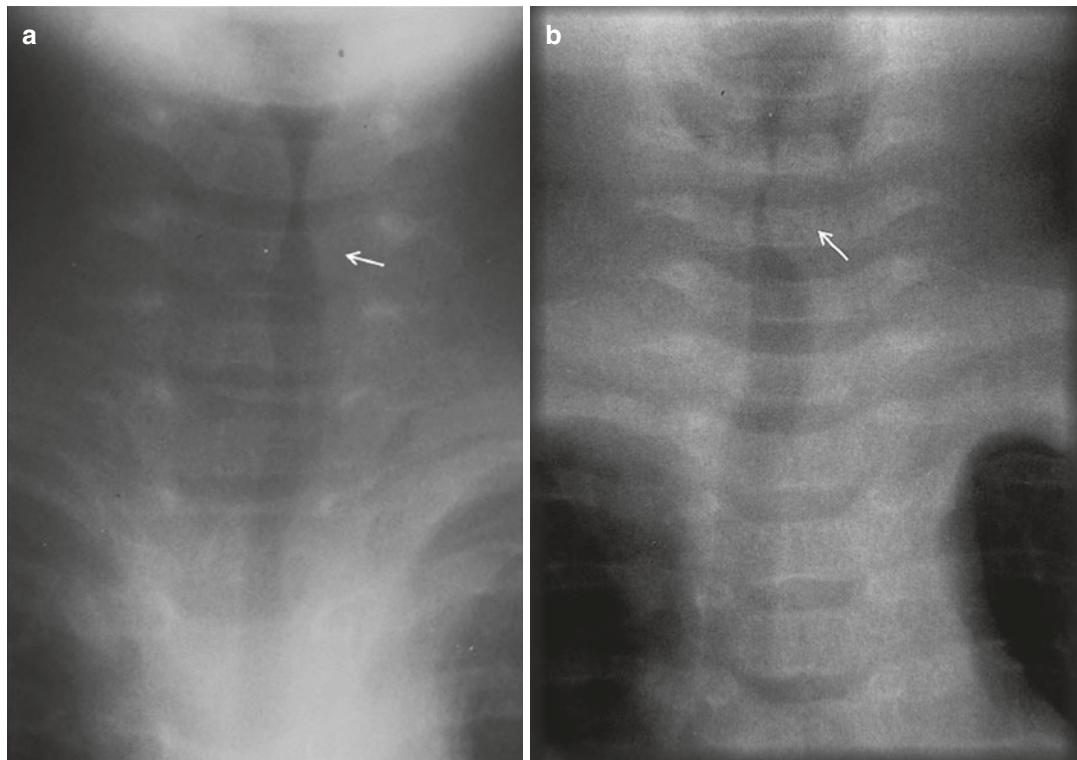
(a) Frontal radiograph of the airway of a 2-year-old boy, showing the typical symmetrical “steeple sign” (arrow), which is suggestive of croup. (b) There is
